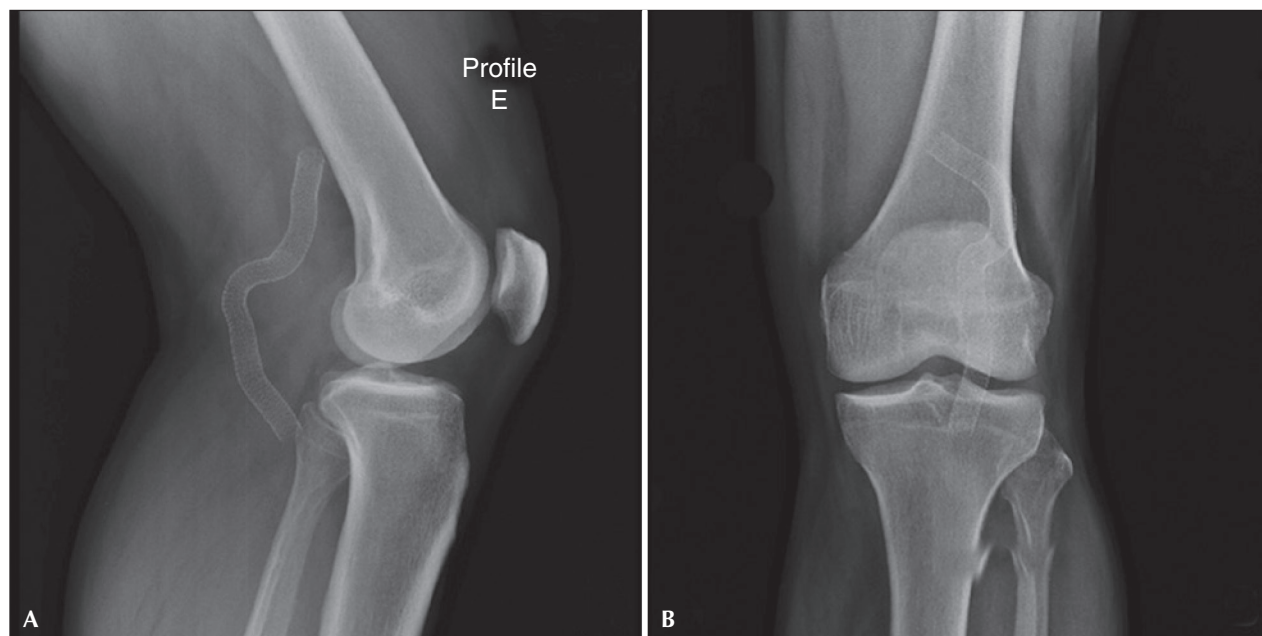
Follow-up X-ray after endoprosthesis implantation. (A) Left profile with knee in semiflexion. (B) Posteroanterior view, both showing no signs of fracture.
